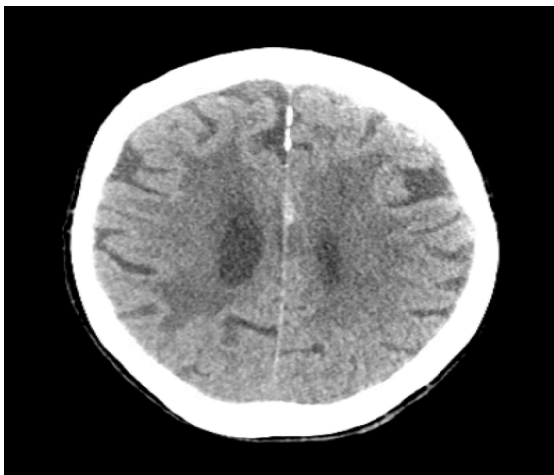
CT Head without contrast showing an acute trace left parafalcine subdural hematoma. No associated mass effect. There is moderate size left occipital calvarial contusion/hematoma without underlying calvarial fracture.
